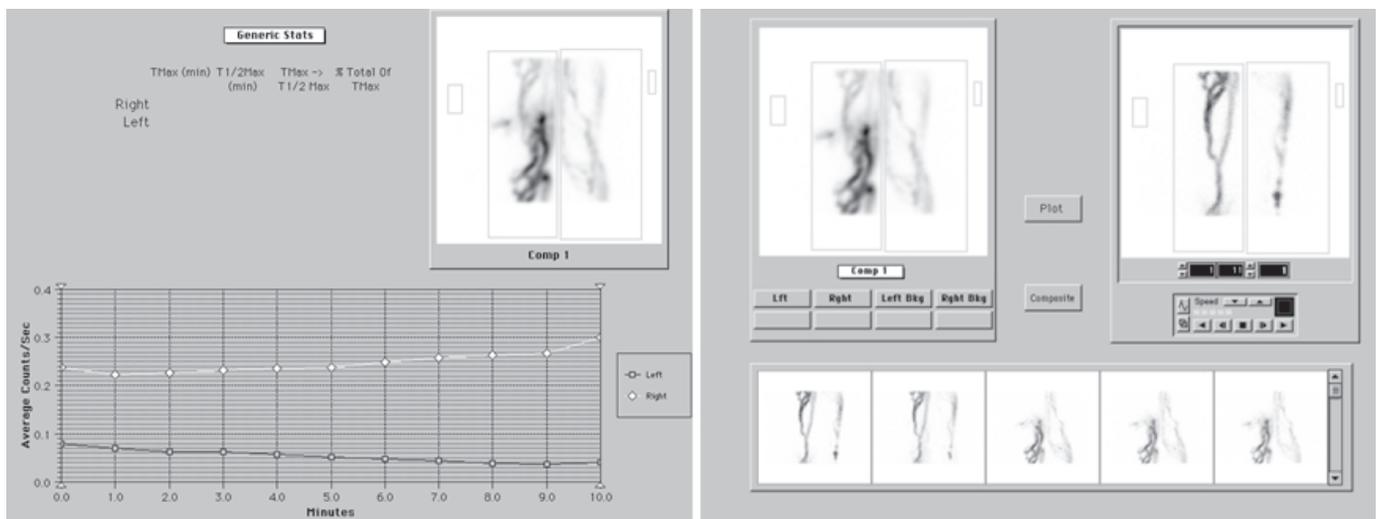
M.C. – dynamic lymphoscintigram of lower limbs in 2006, dynamic acquisition time 10 min. Visible accumulation of the radiotracer in the network of dilated lymphatics in the right limb; quantitative analysis (radiotracer activity curves) confirms lymph obstruction on the right side (increasing trend in the right limb)
